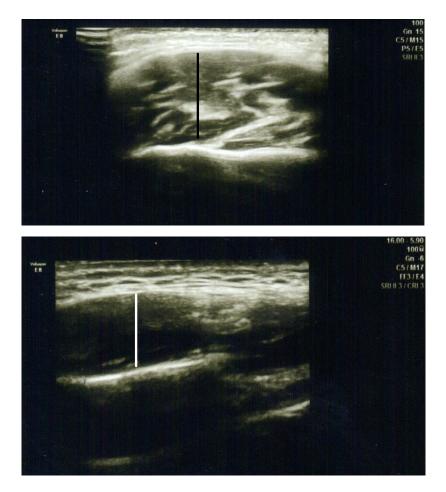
Ultrasonography of masseter muscle
